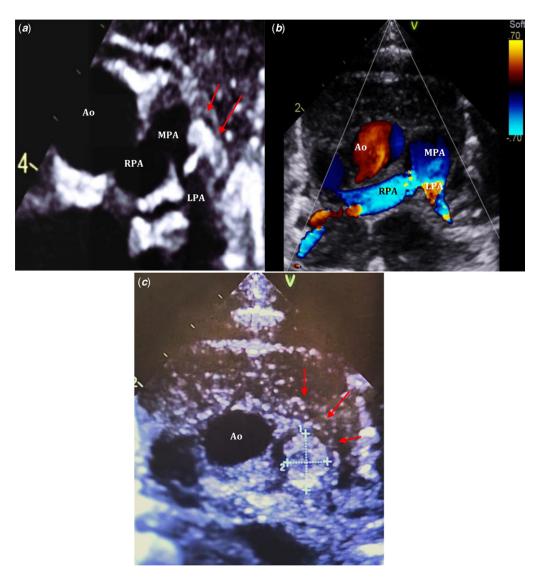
Transthoracic echocardiogram, parasternal short axis, demonstrating: (*a*) and (*b*) thrombus protuding to the left pulmonary artery end of the arterial duct (*c*) throumbus in the main pulmonary artey. Ao = Aorta; LPA = left pulmonary artery; MPA = main pulmonary artery; RPA = right pulmonary artery; arrows = thrombus.
